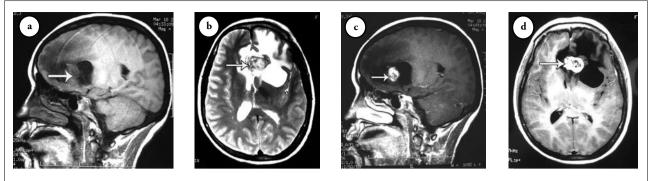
The MRI showed an intracerebral lesion accompanied by a cystic-solid lesion and remarkable peritumoral edema. a) Sagittal T1-weighted image showed isointense-signal intensity mass (arrow). b) Hyperintense-signal intensity on Axial T2 weighted image (arrow). c & d) The nodule with a significant enhancement by GD-DTPA (arrows).
